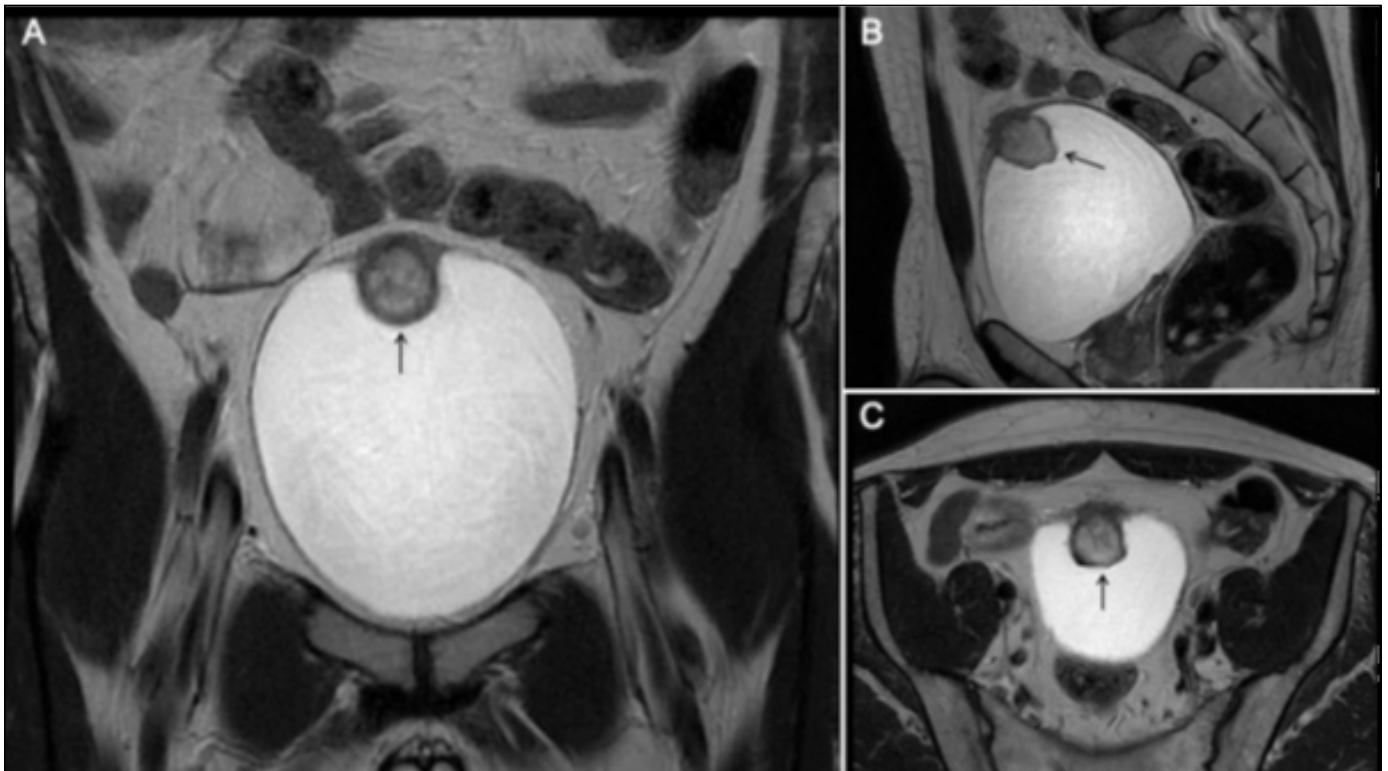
Multiparametric MRI scan showing a bladder wall lesion (arrows) on T2-weighted images. A. Coronal, B. Sagittal, and C. Axial views with a well-defined mass arising from the posterior bladder wall.
